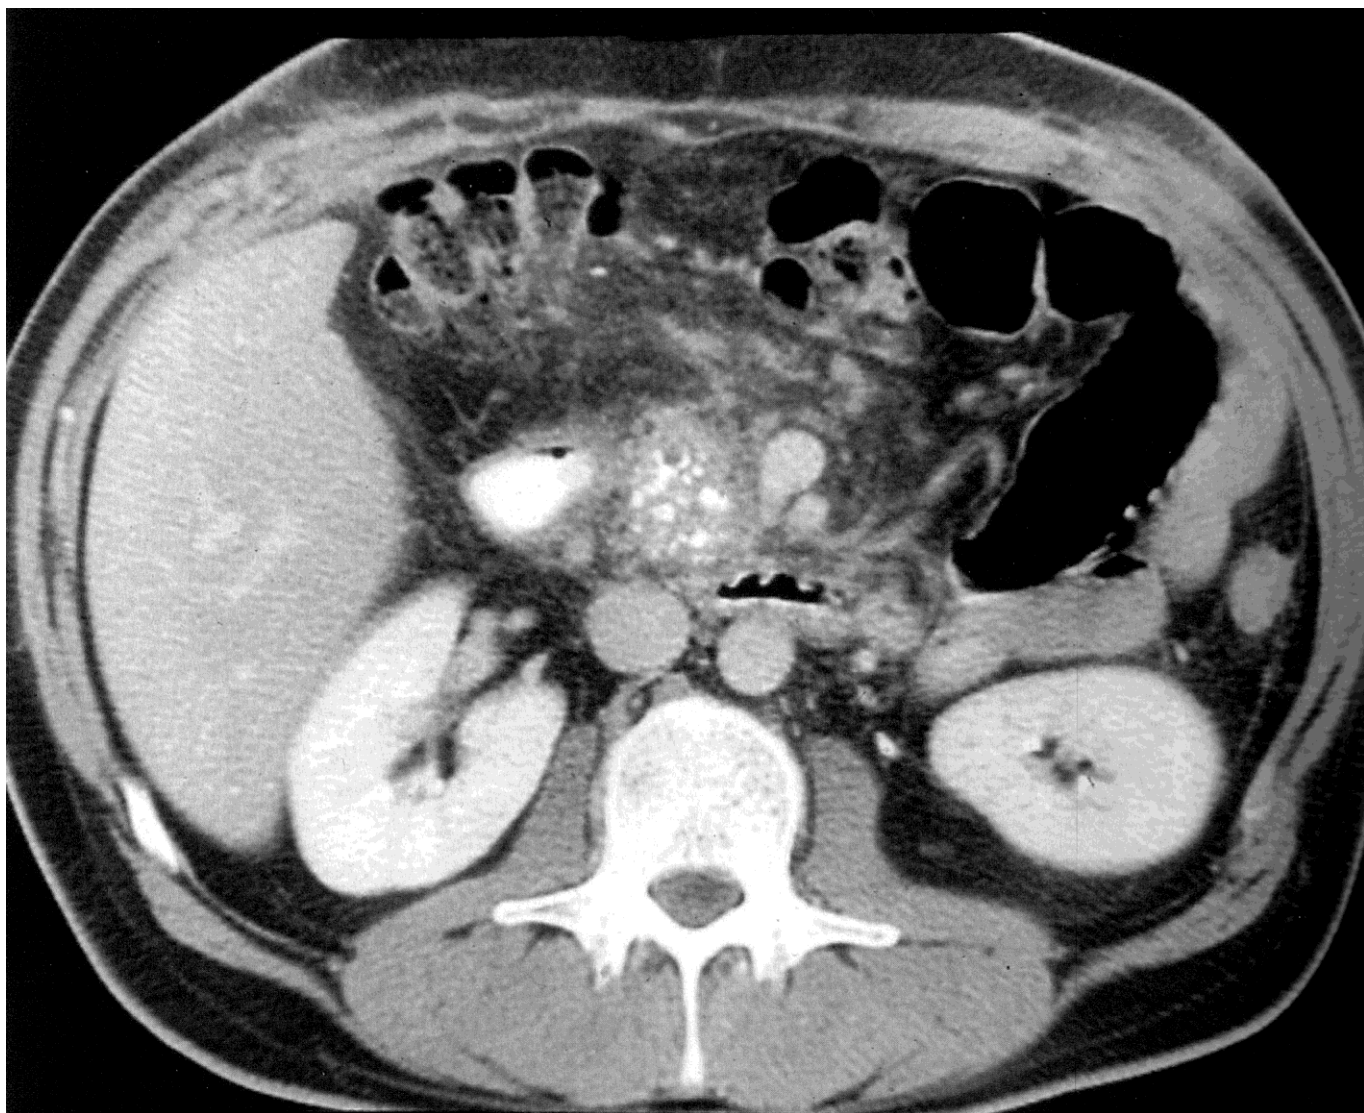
When CT patient with NP determined multiple calcifications in the pancreatic head. In peripancreatic tissue — adhesive process (for C. D. Johnson et al, 2005 [1, 20]).
